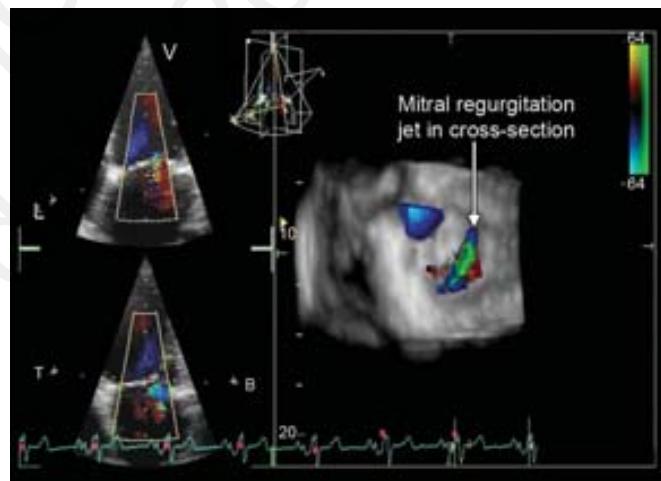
Use of three-dimensional echocardiography for visualization and quantification of the shape and the size of the mitral regurgitation vena contracta.
